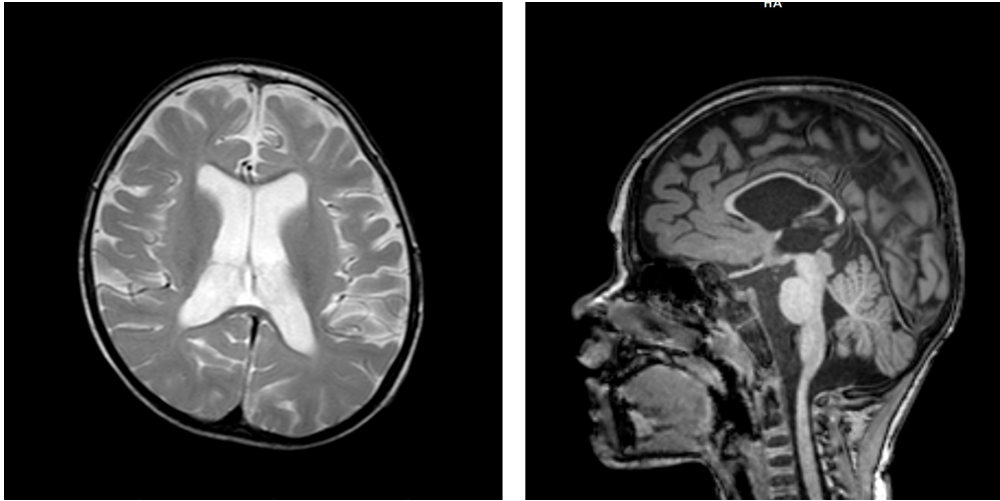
Brain MRI of the first patient: (a) T2-weighted axial image showing cerebral atrophy and ventricular dilatation; (b) T1-weighted sagittal image showing cerebral, cerebellar atrophy and thinning of the corpus callosum
